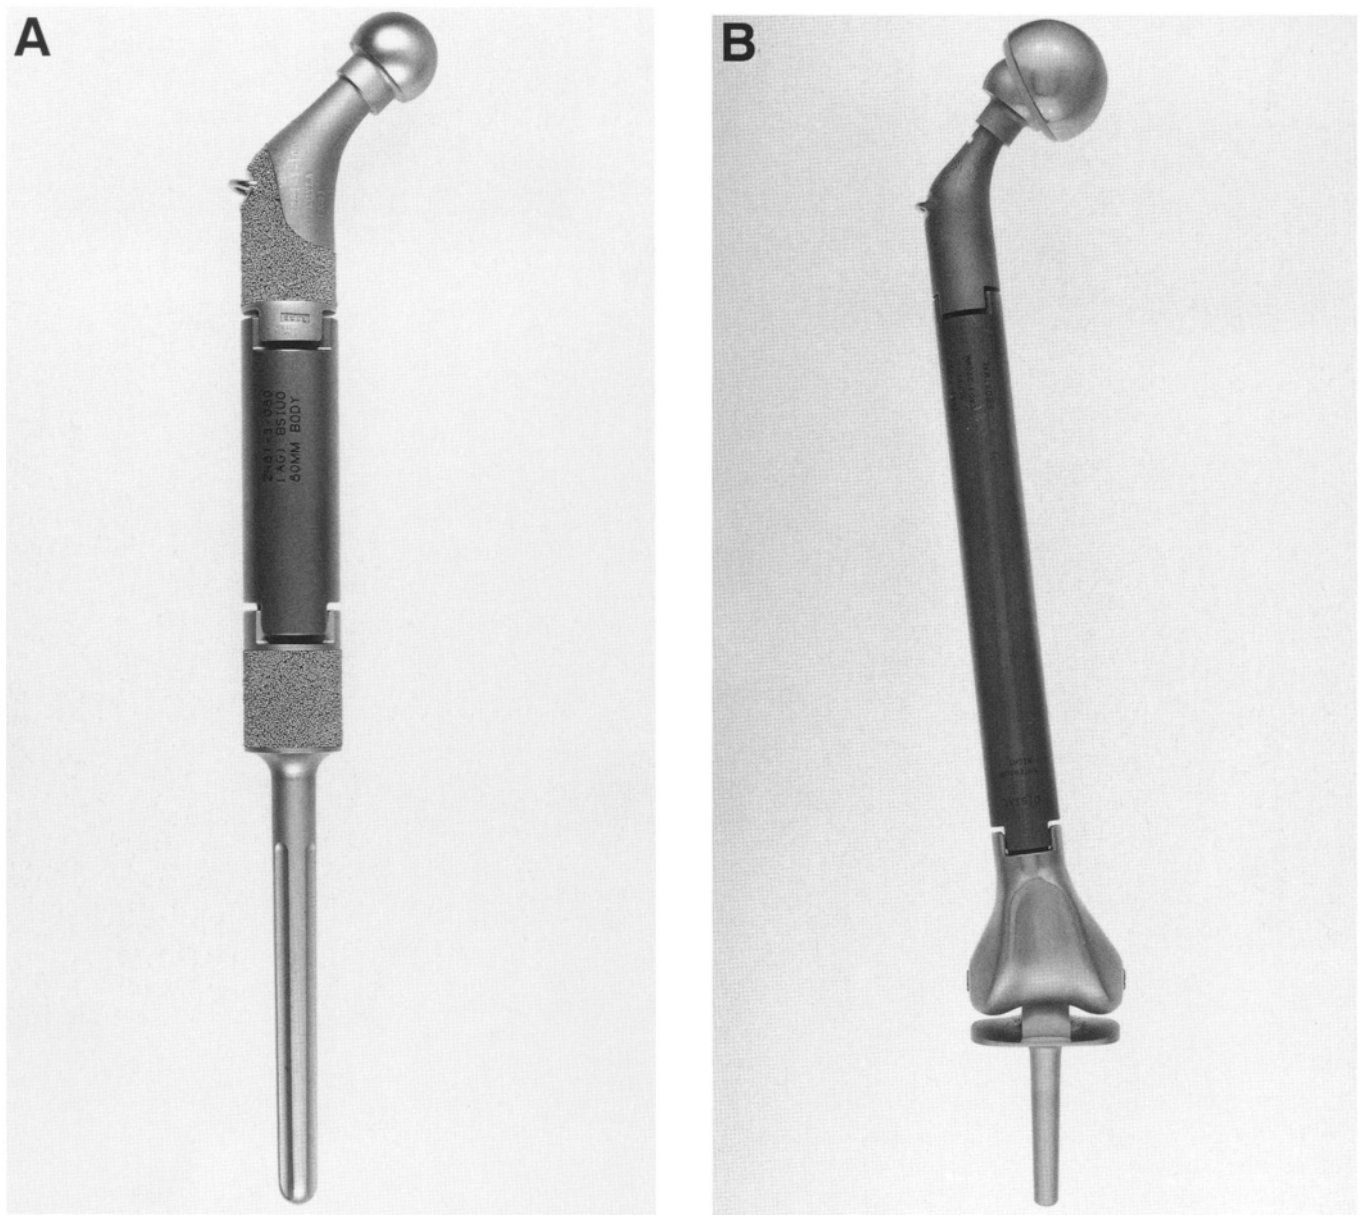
(see also following page) Modular prostheses. (A) Proximal femur, and (B) total femur (Howmedica, Rutherford, NJ). (C) Plain anteroposterior radiograph of the pelvis and lower extremities, showing a modular proximal femur prosthesis with a bipolar head in a 31-year-old patient with Ewing's sarcoma. The greater trochanter was spared and reconstructed with a cable grip system.
